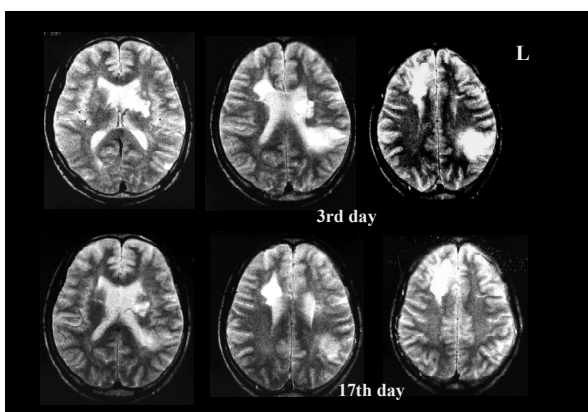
MRI of the brain in Case 3 with acute and chronic diving accidents
